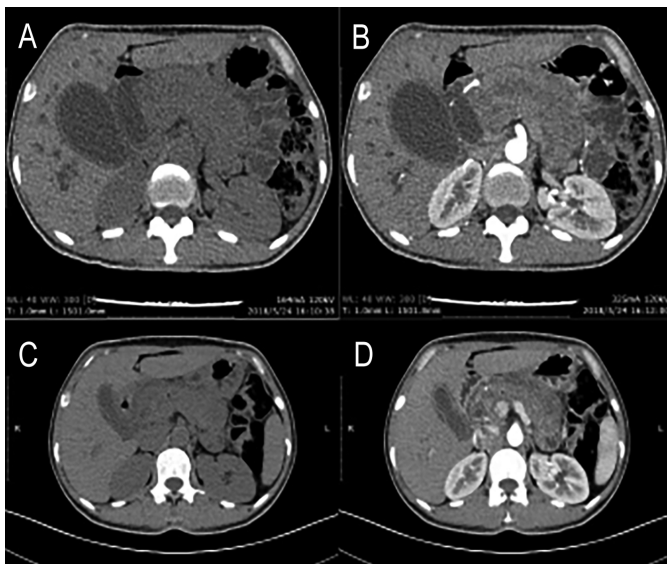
(A, B) CT showing diffuse enlargement of the pancreas, with a sausage-like appearance, with a longer delay in heterogeneity after angiography. (C, D) After 6 cycles of chemotherapy, the diffuse enlargement of pancreas had decreased significantly.
